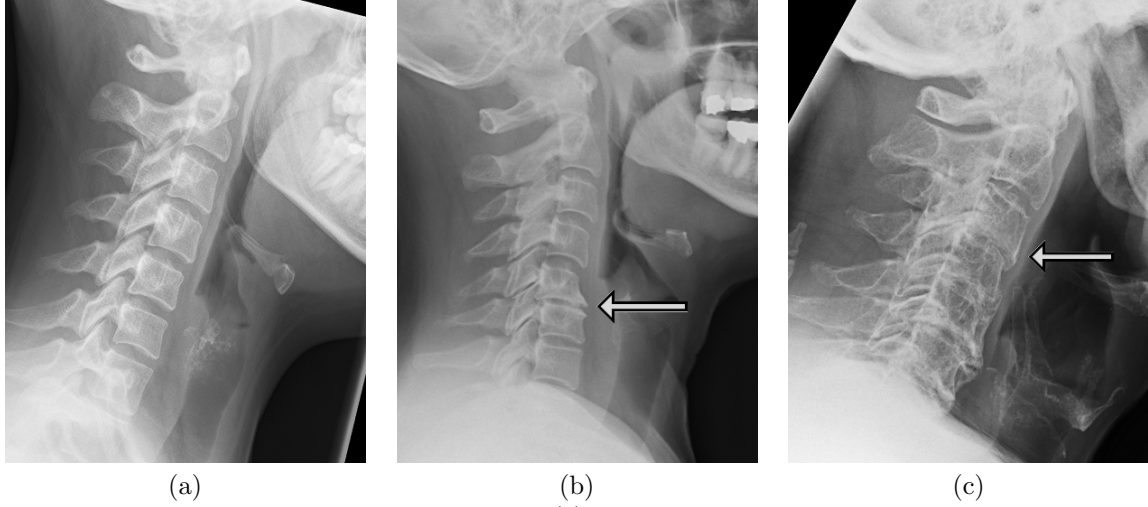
Three lateral view cervical spine radiographs. In (a), a normal cervical spine x-ray image of a 20 year old patient is shown; notice the separation between vertebral bodies and good contrast at vertebral body edges. In (b), an image of a 55 year old patient is shown, with an example of degenerative change (poor vertebrae spacing, osteophyte) indicated. In (c), an example of an 82 year patient with severe degenerative changes is shown; note the lack of identifiable superior and inferior vertebral boundaries as well as vertebral spacing, for example at the point indicated by the arrow.
